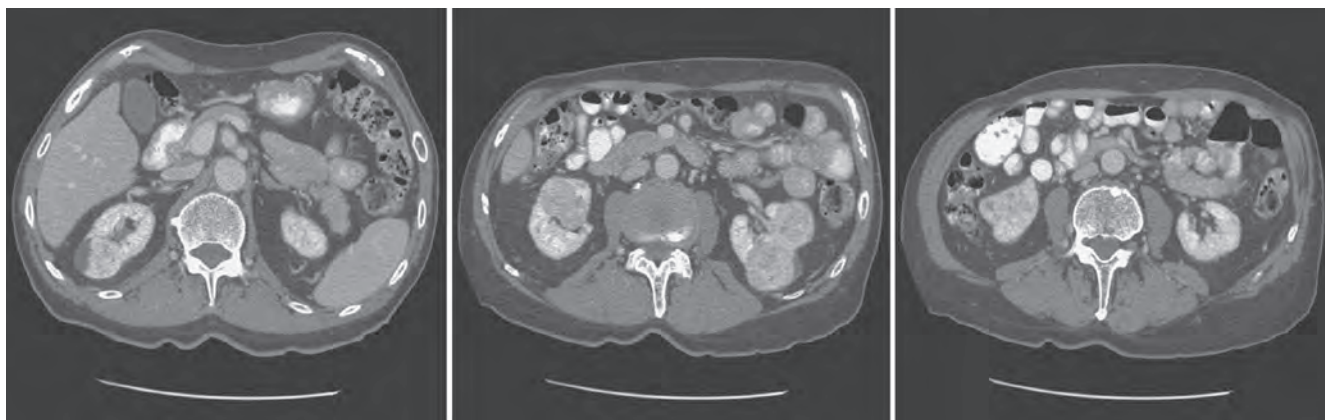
Computed tomography scan of a patient with multiple bilateral oncocytomas.
